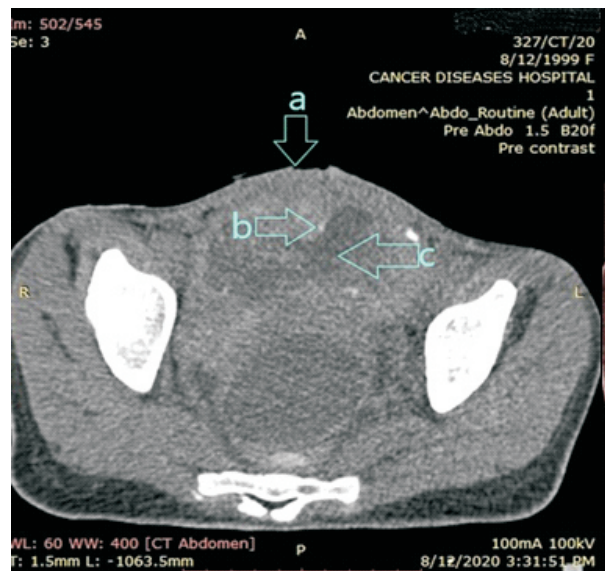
CT scan without contrast showing; A: anterior abdominal wall, B: calcifications, and C: heterogenous mass.
